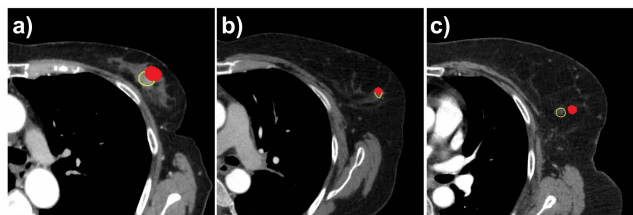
Visual examples of the prone to supine tumor displacement. CT images of 3 cases: the blue mask is the region of the prone breast volume, the green line is the outline of the artificial supine breast volume, the magenta and yellow regions outline the prone and supine tumor respectively. The three cases differ in the amount of displacement of the tumor from prone to supine position: a) small b) medium c) large.
